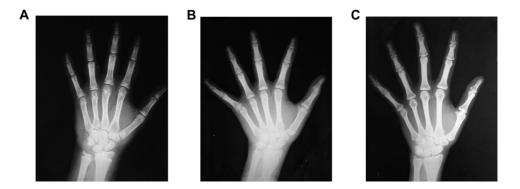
Hand–wrist radiograph of a pre-pubertal (A), pubertal (B), and adult (C) subject based on the methods of assessment of Björk and Grave and Brown.
